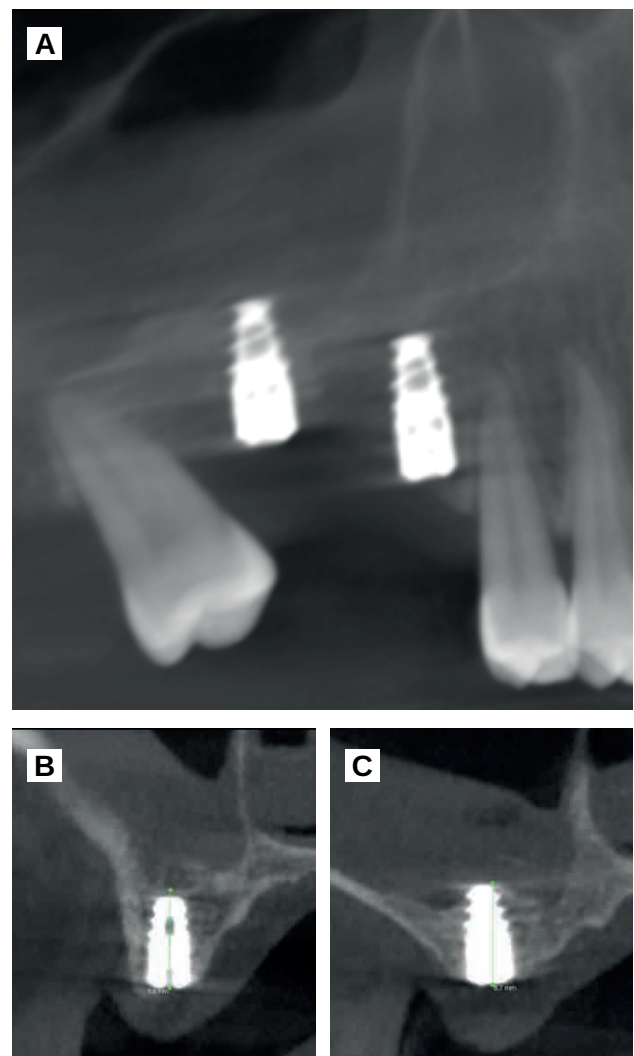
A. CBCT at six months following placement of the implants. B. Final height of 9.2 mm in the 1.6 region. C. Final height of 8.7 mm in the 1.7 region.
